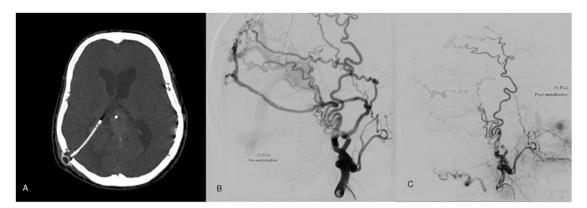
A- Brain CT scan showing the catheter of V-P shunt, a hyperdense fungating mass of A-V fistula, B-Right MMA angiography before the first embolization session, C- Right MMA after embolization.
